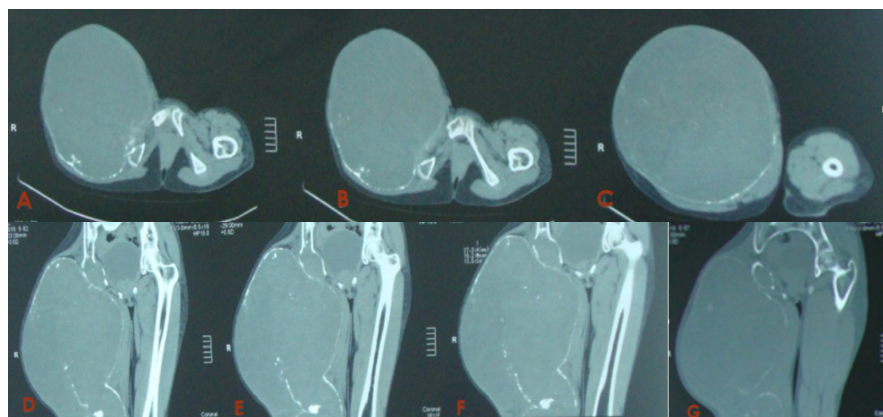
CT scan of the right femur and hip in axial sections (A, B and C) with coronal reconstruction (D, E, F and G) in parenchymal and bone windows (G) without IV injection of contrast medium, showing a voluminous fluid collection occupying the entire right femur and extending to the right femoral head and homolateral ischium. Note the local interruption of the cortical bone and the displacement of adjacent soft tissue, which was thinned or laminated but not infiltrated.
